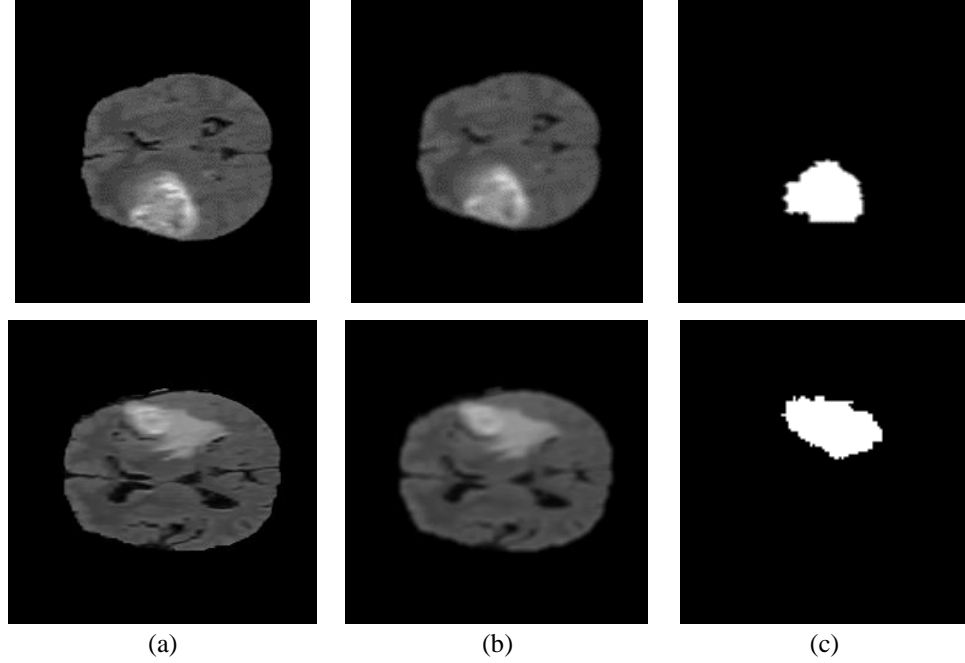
Image results showing (a) Input MRI image, (b) Pre-processed image, (c) Segmented image
